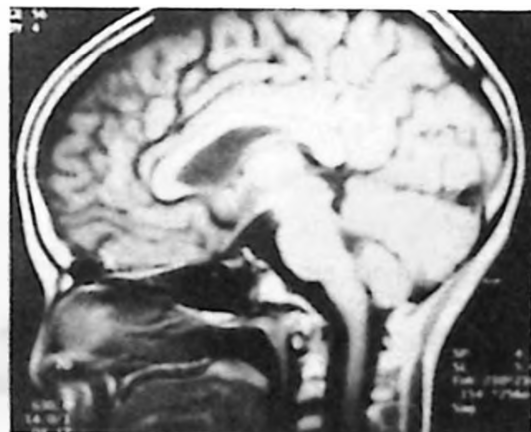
MRI of the brain after chemotherapy shows no suprasellar mass (Case 7).
